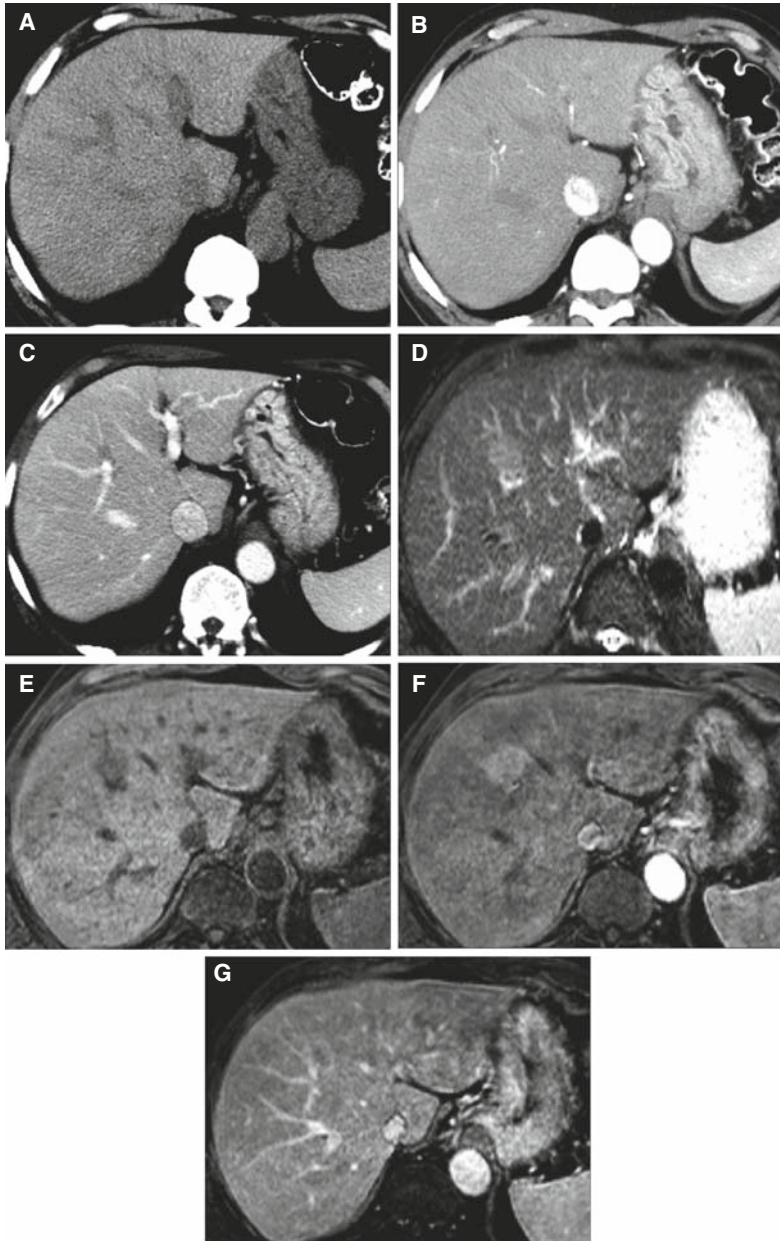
HCC visible by MRI but not three-phase CT. A–C. CT images prior to and during arterial and venous phases of contrast enhancement. D. T2-weighted MR image shows hyperintense HCC. E. T1-weighted MR image shows hypointense HCC. F. As in E, immediately after gadolinium contrast agent administration shows moderately hypervascular HCC. G. As in E, about 1 minute after gadolinium contrast agent administration does not show the HCC, similar to CT.
